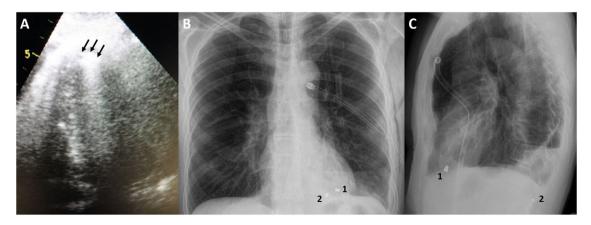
(A) Four-chamber view, transthoracic echocardiogram, showing the echolucent bullet at the apical myocardium with acoustic shadow (arrow). (B and C) Chest X-ray depicting a left-sided pneumohemothorax and two bullets, one at the site of the cardiac apex (B1 and C1) and the second at the spinous process of the 12th thoracic vertebra (B2 and C2).
